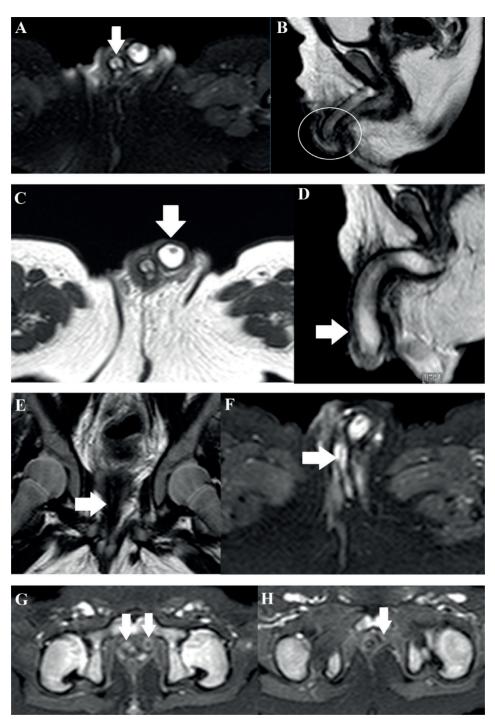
A: MRI in the axial section in the T2 FAT SAT sequence. B: MRI in the sagittal section in the T2 sequence showing the appearance of the urethra of the right penis (white arrow and circle). C: MRI in the axial view and D: in the sagittal view in the T2 sequence showing a single mass of the corpus cavernosum in the left penis (white arrows). E: MRI in the coronal section in the T2 sequence. F: MRI in the axial section in the T2 FAT SAT sequence showing the right urethra opening into the corpus spongiosum (white arrows). G: MRI in the axial section in T2 FAT SAT sequence showing the two urethrae (white arrows). H: MRI in the axial section in the T2 FAT SAT sequence showing the two urethrae (white arrows). H: MRI in the axial section in the T2 FAT SAT sequence showing the left urethra ending in a blind bottom (white arrow).
